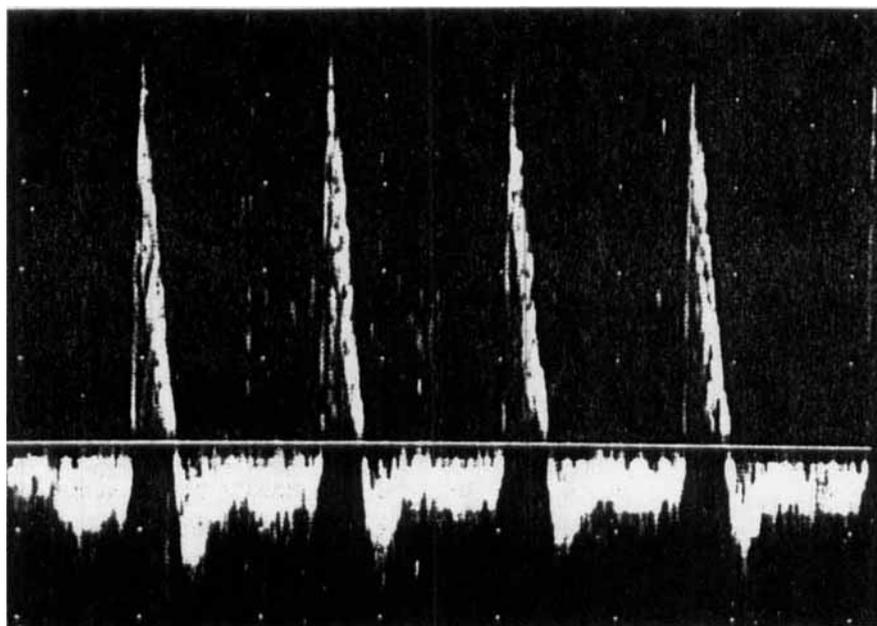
Doppler signals of a renal allograft in mild acute rejection with decreased but still demonstrable diastolic flow
